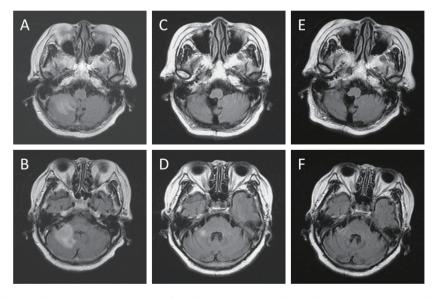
Serial brain MRI changes on T2-weighted FLAIR imaging. The brain MRI just before craniectomy (A and B), 6 months after immunosuppressant therapy (C and D), and one year after therapy showed regression of lesions (E and F). FLAIR: Fluid Attenuated Inversion Recovery
